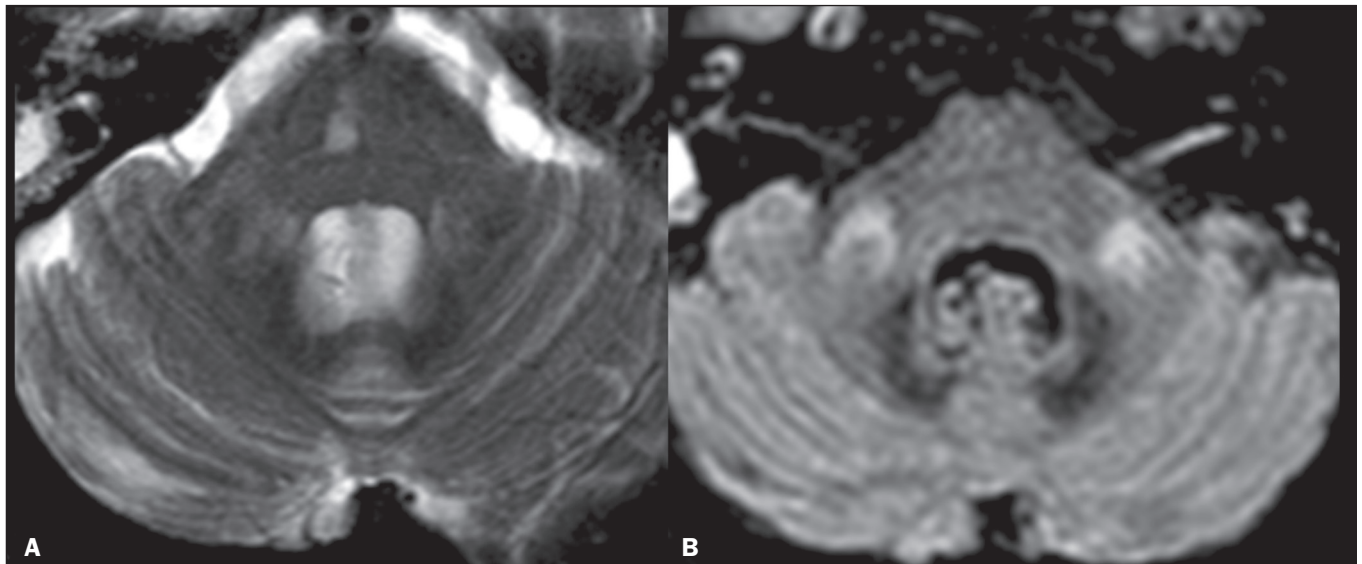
Wallerian degeneration. A: Axial T2WI showing hyperintensity (suggestive of sequelae of infarction) in the right hemi-pons. B: Axial FLAIR sequence showing hyperintensity in both MCPs. These findings are suggestive of Wallerian degeneration caused by a PI.
